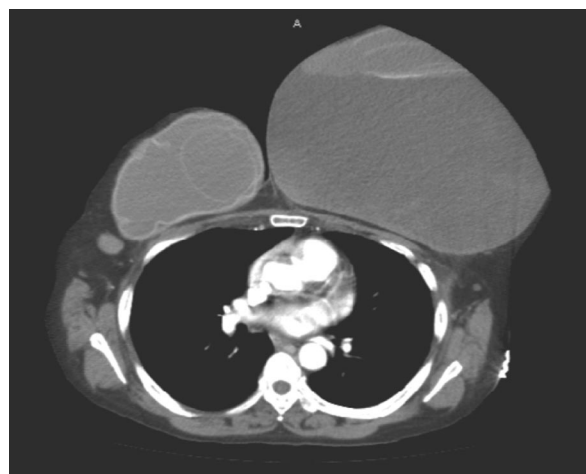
Computed tomographic scan of the chest reveals a large heterogeneous fluid collection within the left breast, a well-demarcated plane between this collection and the pectoralis major muscle, and bilateral implant rupture.
